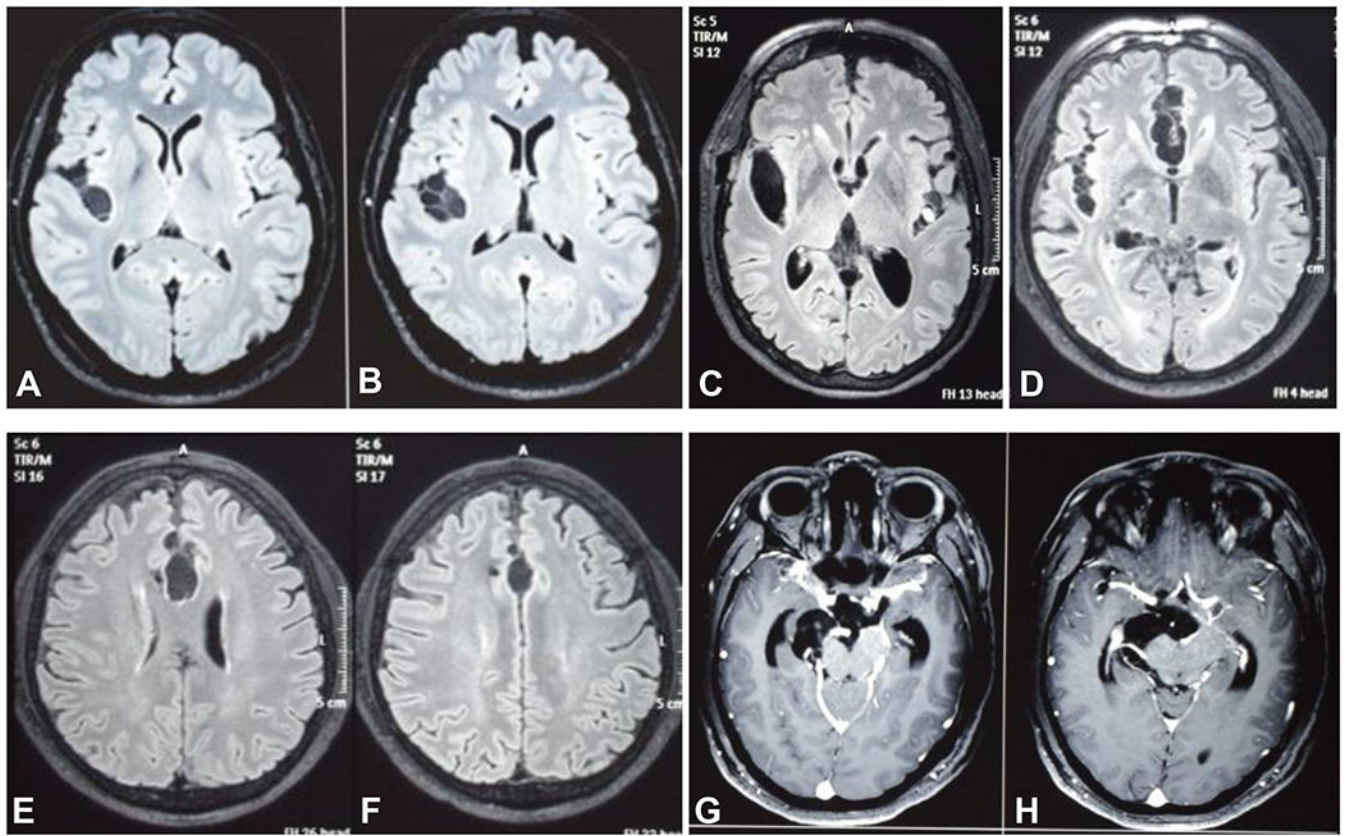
Subarachnoid NCC. A - C) Sylvian; D) lower interhemispheric; E,F) upper interhemispheric; G,H) surrounding the brainstem (A to F, non-contrast MRI FLAIR; G and H, post contrast T1-weighted images).
